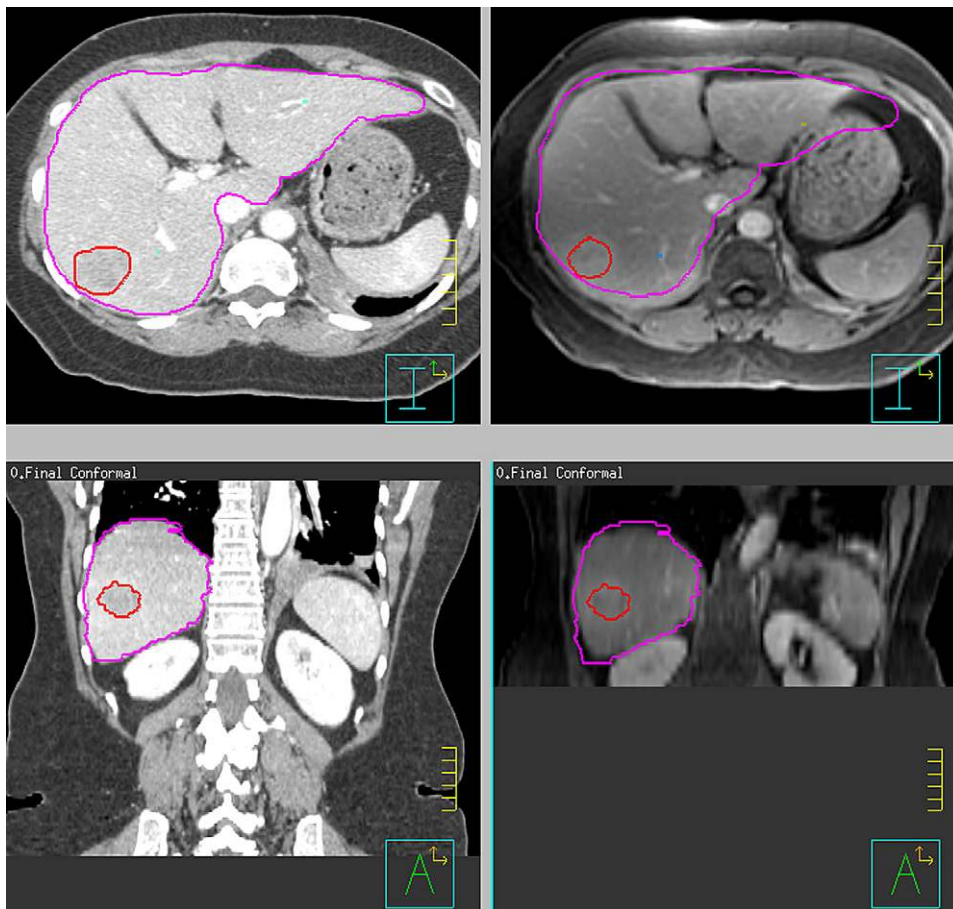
Exhale, 50% phase reconstruction from the four-dimensional computed tomography (left) voluntary exhale breath hold magnetic resonance images (right) obtained for the example liver patient. The liver (pink) and tumor (red) contoured on the exhale images are overlaid onto the magnetic resonance images for reference.
